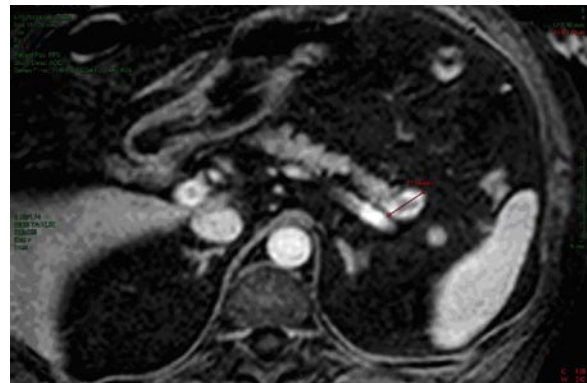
Abdominal magnetic resonance imaging demonstrating a round, well-demarcated nodule of the pancreatic tail. The 22 mm lesion (calipers) shows highly vascularised peripheral tissue.
